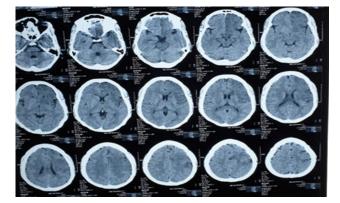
CT scan of brain showing left sided acute cerebral infarct
